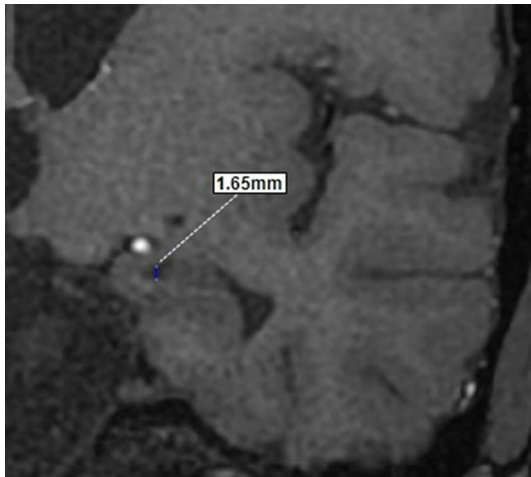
Magnified coronal T1-weighted image of a 54-year old patient with mild OSAS showed vertical measurement of the hippocampal sulcus on left side
